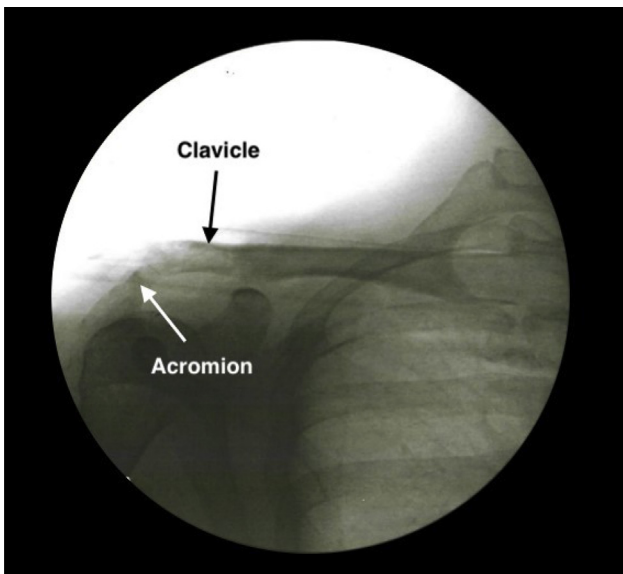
Final radiograph of the distal clavicle and acromion of the right shoulder confirms proper anatomical reduction using combined acromioclavicular and coracoclavicular joint reconstruction with allograft using suture cerclage tensioning system.
